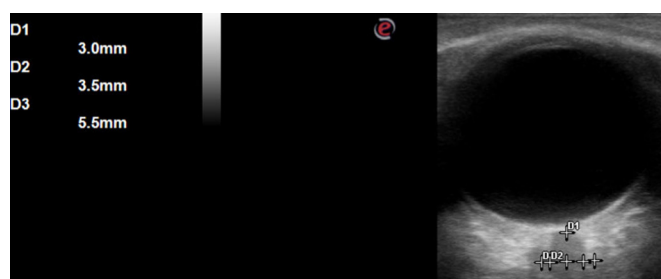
Transbulbar sonography of the optic nerve shows OND (D2) and ONSD (D3) that were measured as identified protocols. Here you can see the optic nerve as a markedly hypoechoic tubular structure with a hyperechoic sheath surrounding it. OND is measured by adjusting the cursor 3 mm behind the retina (marked at D1 site) and just at the edges of the nerve hypoechoic area we adjust the 2 marks of cursor while ONSD is measured by adjusting cursor mark just outside the hyperechoic margins of the nerve. OND, optic nerve diameter; ONSD, optic nerve sheath diameter.
